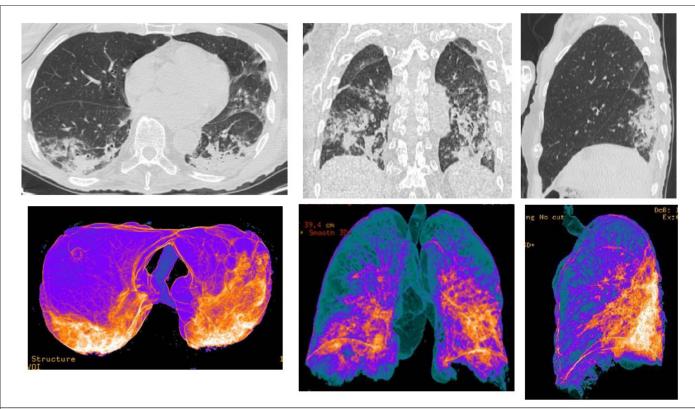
CT patterns of bilateral Covid-19 pneumonia of a 75-year-old male patient. In the upper line, MPR (axial, coronal, sagittal) reconstructions, that showed bilateral typical "ground-glass" areas, with interstitial thickenings. In the line above, Volume Rendering (VRT) "colored" reconstructions, that indicated as blue the areas representing the normal lung parenchyma, while orange/white areas indicate the inflammatory pulmonary involvements.
